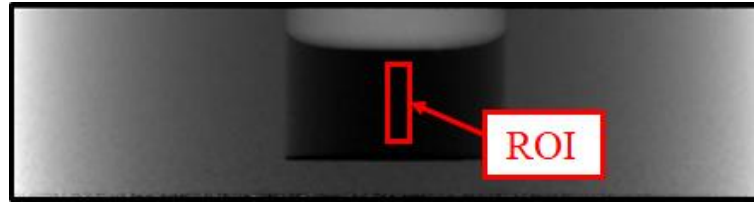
Crop of the 2D map of X-ray transmission at 60 keV with the cavity filled of iodinated solution with a concentration of 32 mg I/ ml. The ROI used for the transmission evaluation is shown.
